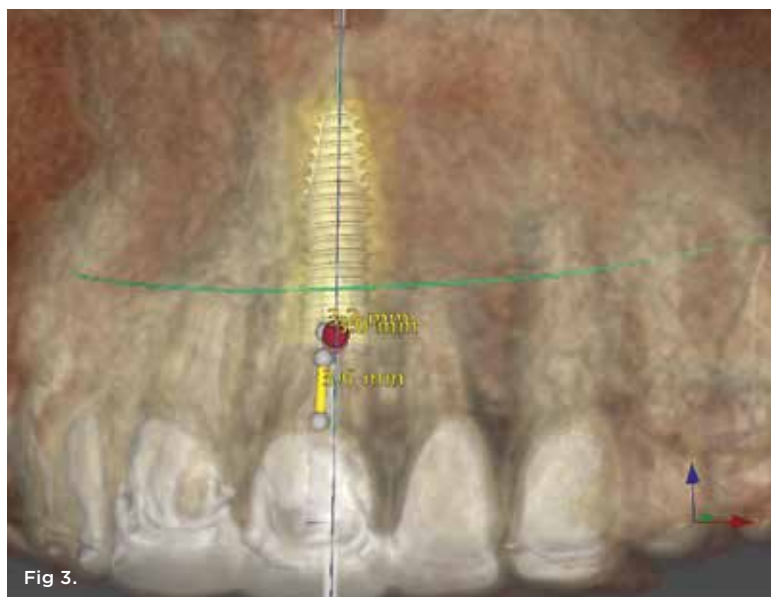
and Fig 4. Pretreatment site-specific CBCT showing thick intact buccal plate and class 1 sagittal root position. Preplanning with a bone-level 4.1-mm diameter implant assured a 3-mm buccal gap upon placement and a screw-retained position. Fig 5. Palatal wall placement of implant. Anatomically correct surgical guide template assured a screw-retained position and correct vertical depth. Fig 6. The 3-mm buccal gap was grafted tightly with low-substitution DBBM, and a pouch was created as a mini full-thickness flap to accept a connective tissue graft.
